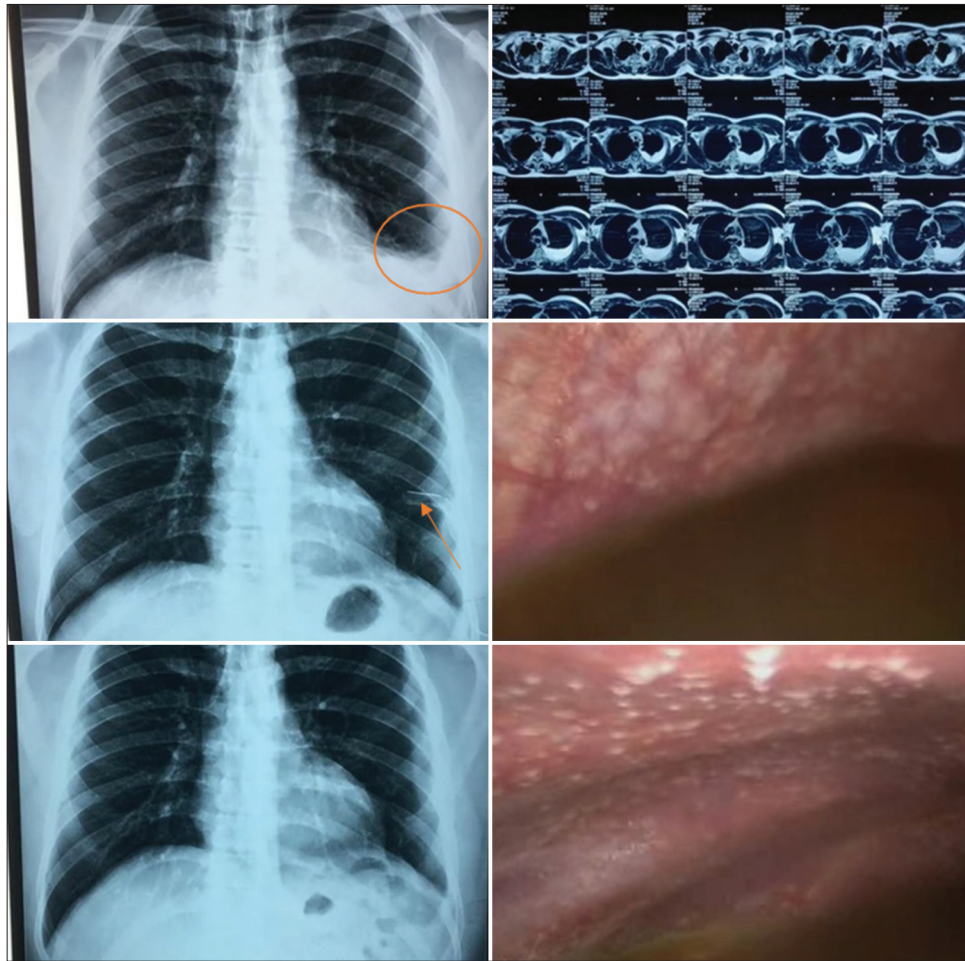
(a-f) Anti-clockwise from top left - (1) Pre-operative chest X-rays (CXR) (blunting of costophrenic angle indicated by circle) posteroanterior (2). Post-operative day 1 CXR (ICD indicated by arrow) (3). POD 14 CXR (4). Pre-operative computed tomography thorax (5 and 6). Intraoperative findings - Nodular lesions on the parietal pleura with effusion 33-year-old male, left-sided pleuritic chest pain
